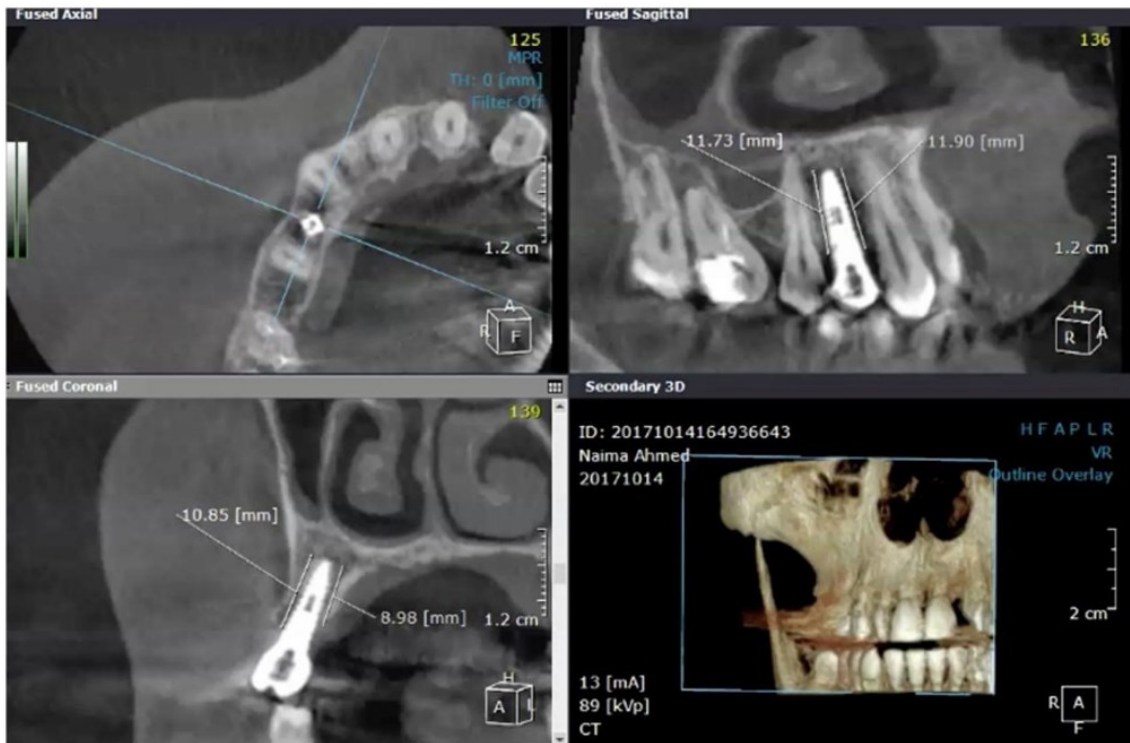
Buccal, palatal, mesial and distal CBCT measurements at baseline.
